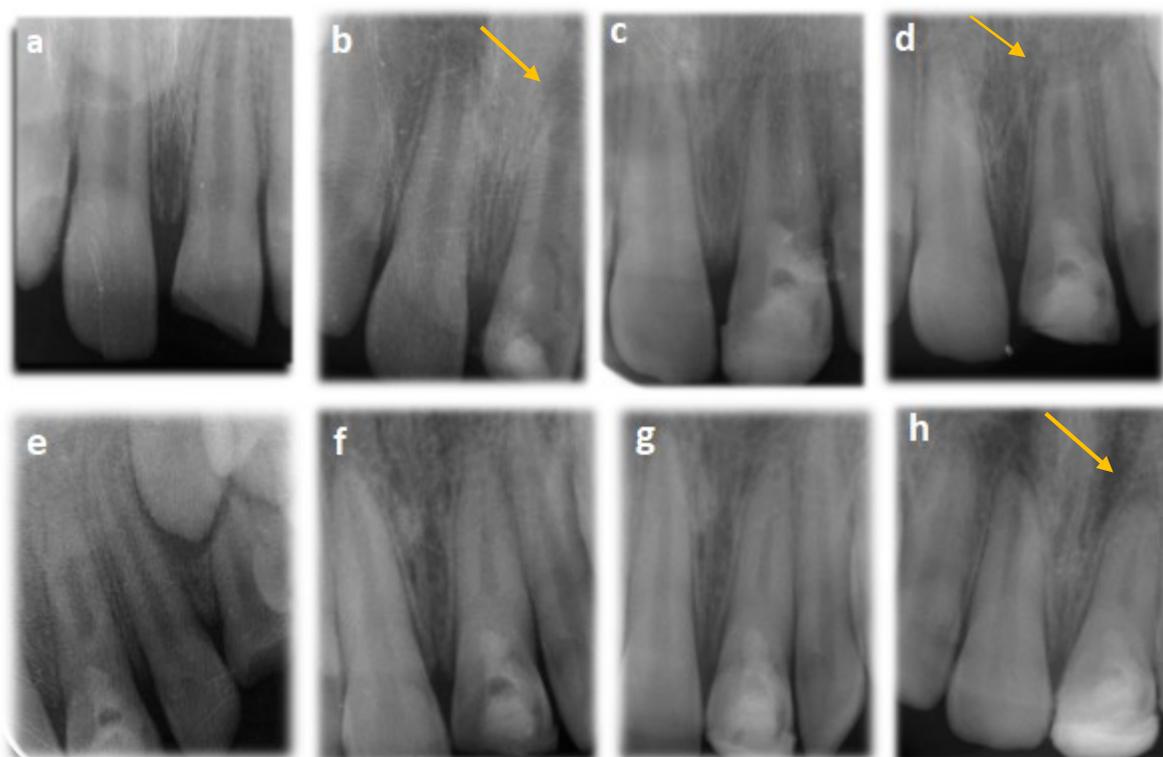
a: Preoperative radiograph; b: Disinfection and intracanal medicament placement in the first session; c: Postoperative radiograph; d: 6-month radiograph; e: 12-month radiograph; f: 24-month radiograph; g: 36-month radiograph; h: 48-month radiograph
